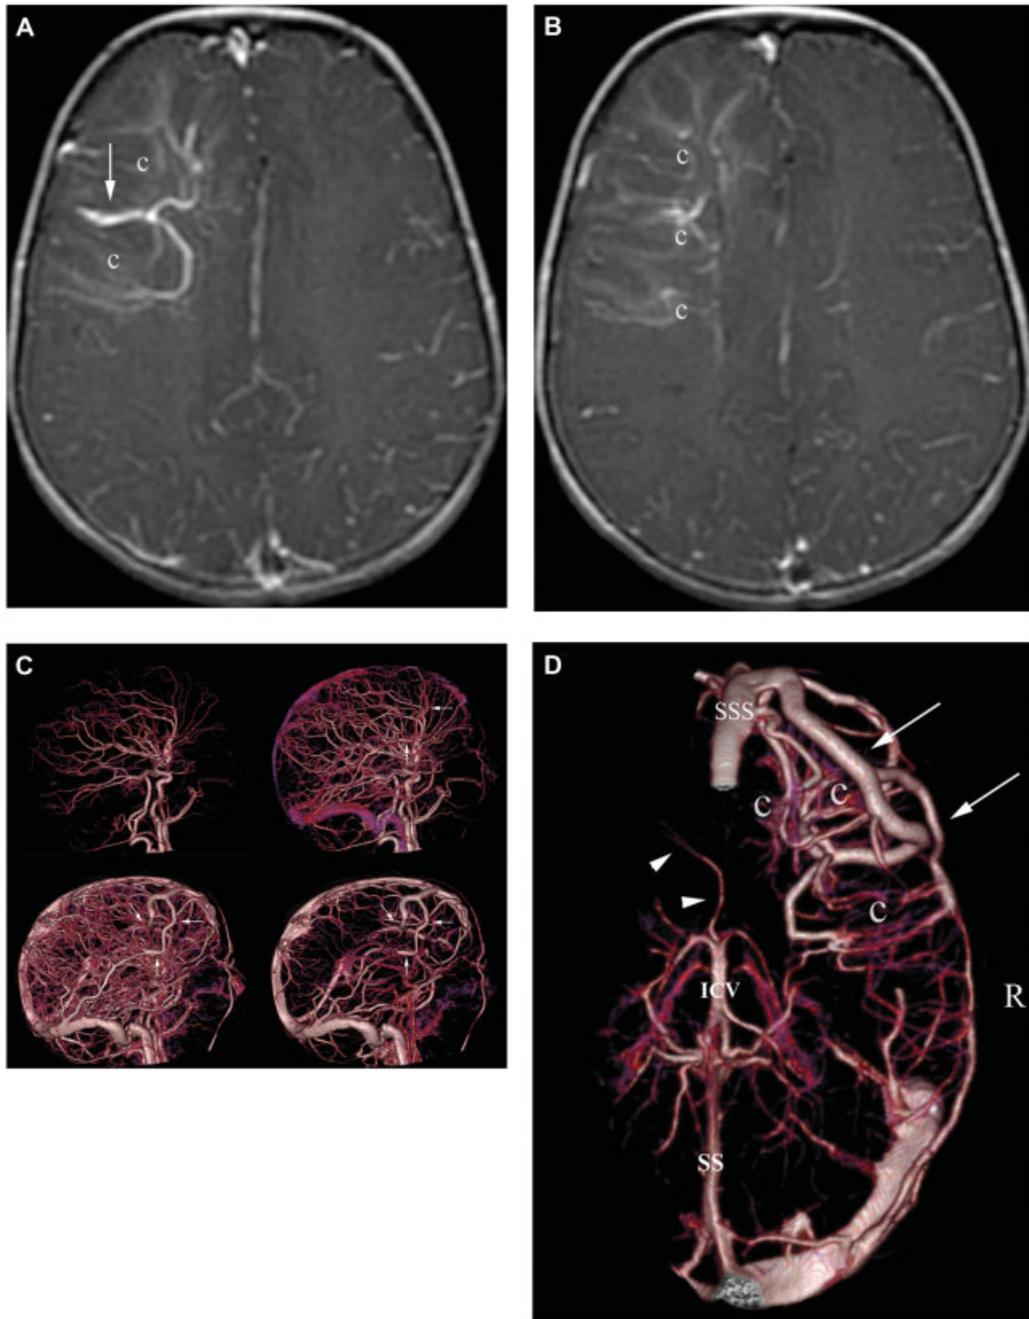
A 4-year-old boy investigated for seizures. (A, B) Gadolinium-enhanced gradient-echo (GE) T1-weighted MRI showing a complex lobar frontal DVA draining superficially into the superior sagittal sinus through several collecting veins (arrows). The caput medusae is well depicted (c); 3D-volume-rendered reconstruction from dynamic subtracted 320-multidetector row CT angiography. (C) Right lateral projection, sequential filling of the intracranial circulation (only four out of the 14 whole-head volumes obtained during dynamic acquisition are shown): arterial phase (top left), beginning of venous filling (top right), intermediary phase with arteries and veins (bottom left), and venous phase (top bottom). The high temporal resolution of the this dynamic subtracted sequence suggests normal filling of the DVA during the venous phase (collecting veins, arrows). Absence of arterialization of this DVA was confirmed through DSA; (D) superior view, the DVA, the deep venous system, and the anterior third of the superior sagittal sinus (SSS) have been segmented. The caput medusae of the DVA (c) are demonstrated along with the various collecting cortical veins that drain into the anterior third of the superior sagittal sinus. The anterior septal vein (arrowheads), tributary of the internal cerebral vein (ICV), is visible on the left side, and is developmentally absent on the right. The DVA drains the territory of the latter. SS = straight sinus; R = right side.
